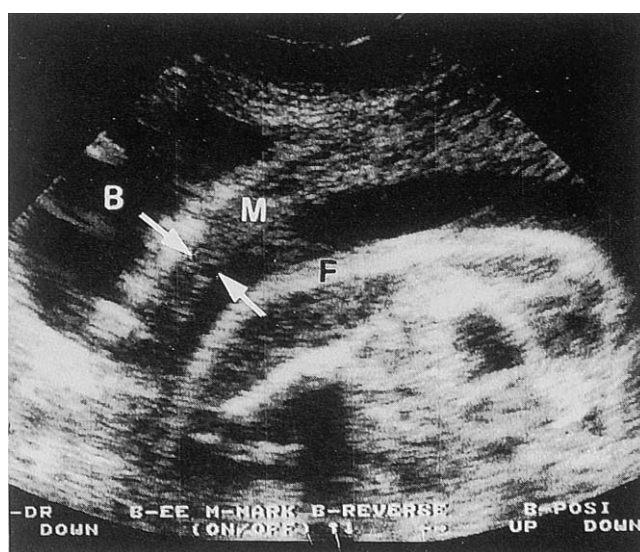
Sonogram of a patient with no previous cesarean section at 25 weeks showing normal symmetrical thickness of myometrium of 5 mm between the arrows. B, bladder; M, myometrium; F, fetus.
